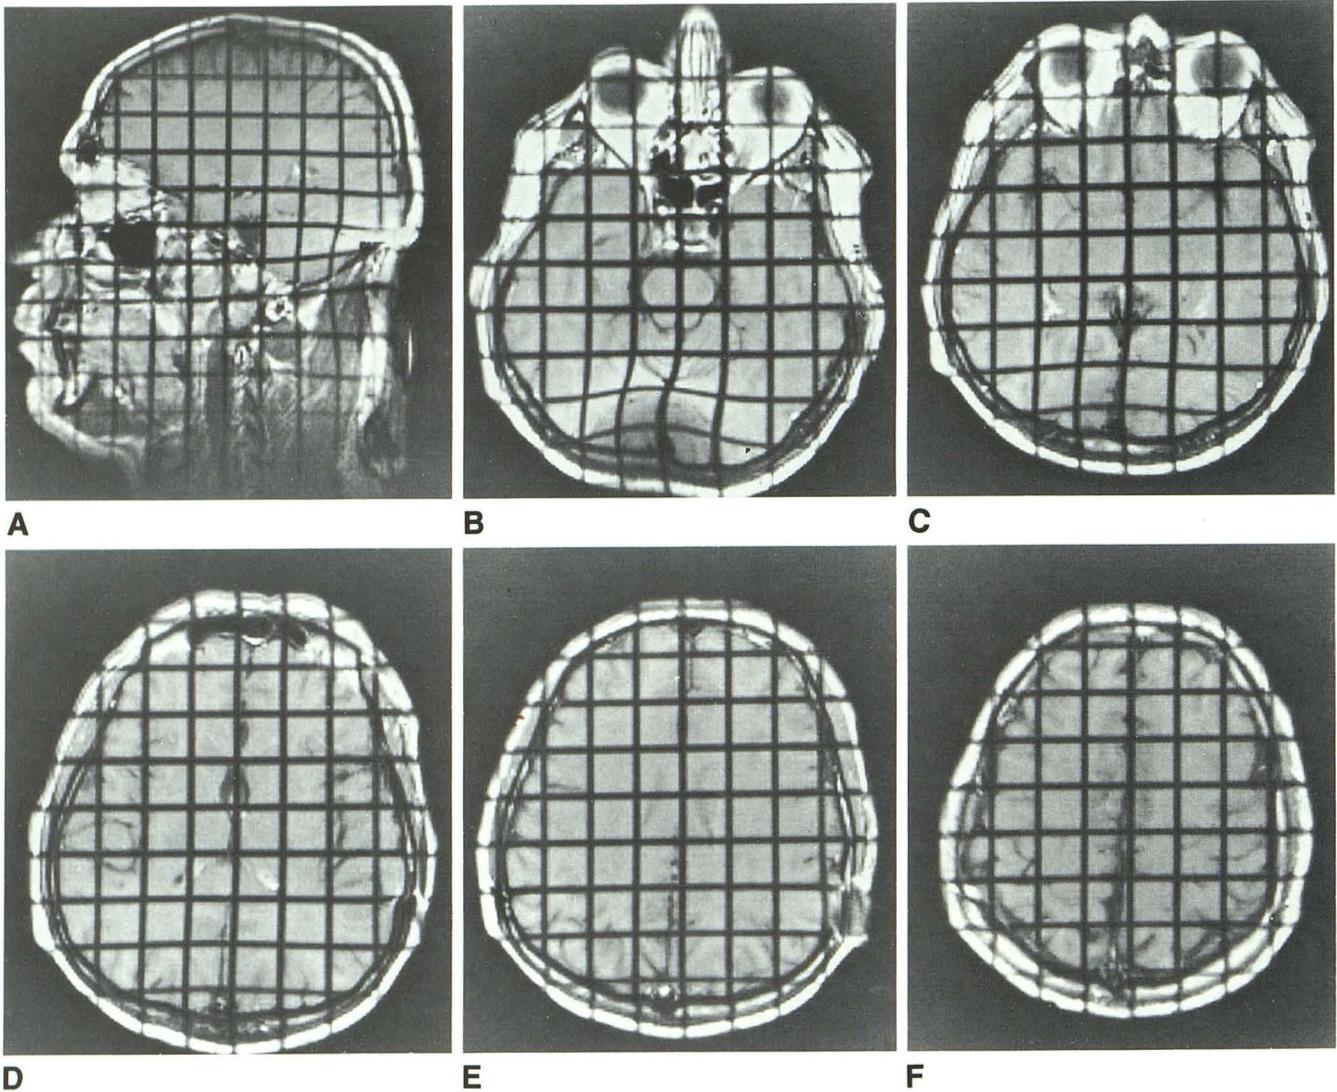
Sagittal (A) and transverse (B-F) T1-weighted DT images of a patient with a needle accidentally left in his occipital scalp (700/20, 256 × 256 matrix, 350-mm field of view, 5-mm thickness, 10-mm intersection gap).
